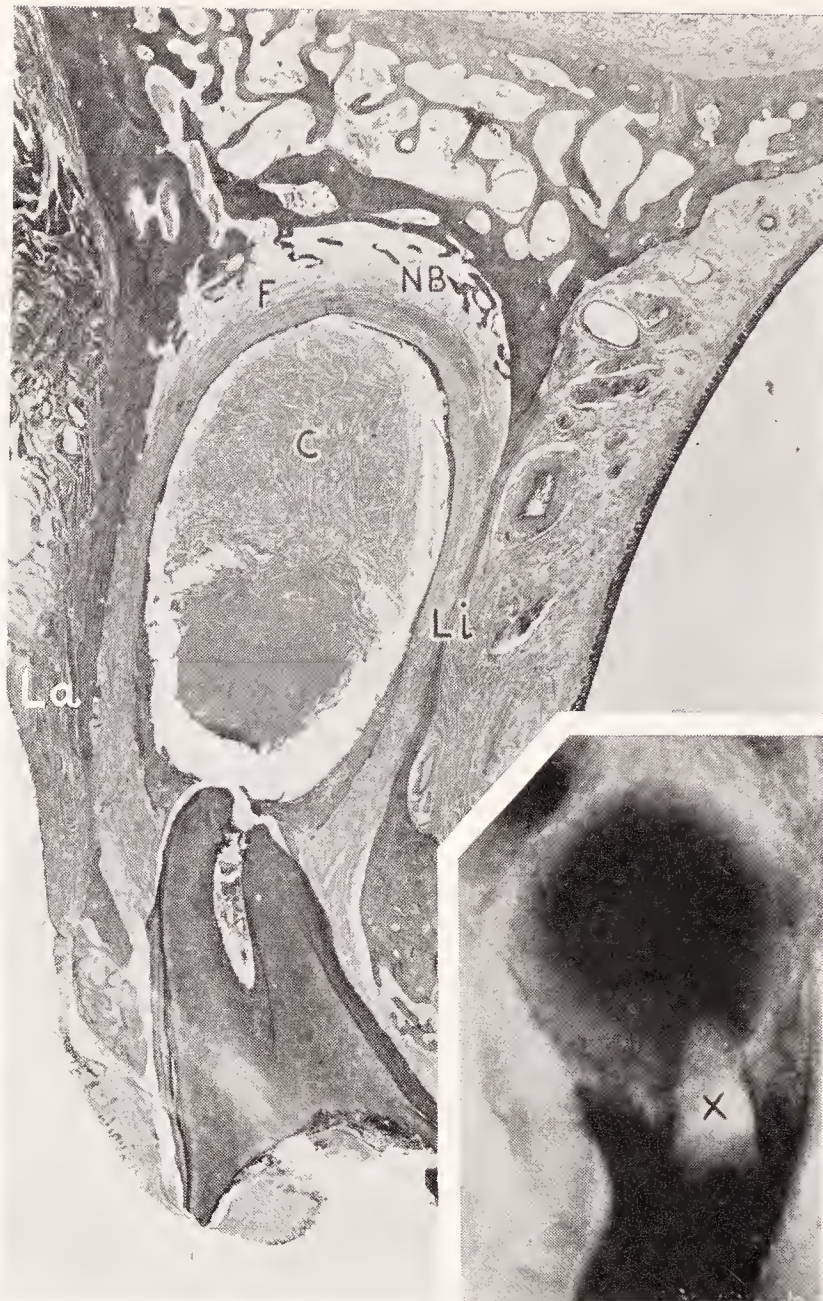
Radicular cyst. The radiograph shows a large round area of bone destruction. Upper cuspid; aged fifty-six years. *C*, cyst cavity containing cholesterol; *F*, fibrous capsule; *NB*, trabeculae of new bone; *La*, *Li*, thin labial and lingual bone plates. (Kronfeld, Australian Dental Congress.)
